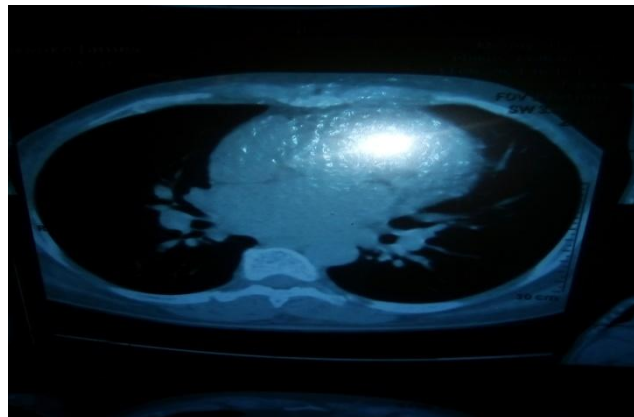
Chest CT Scan of the index patient showing prominent/engorged pulmonary vein
